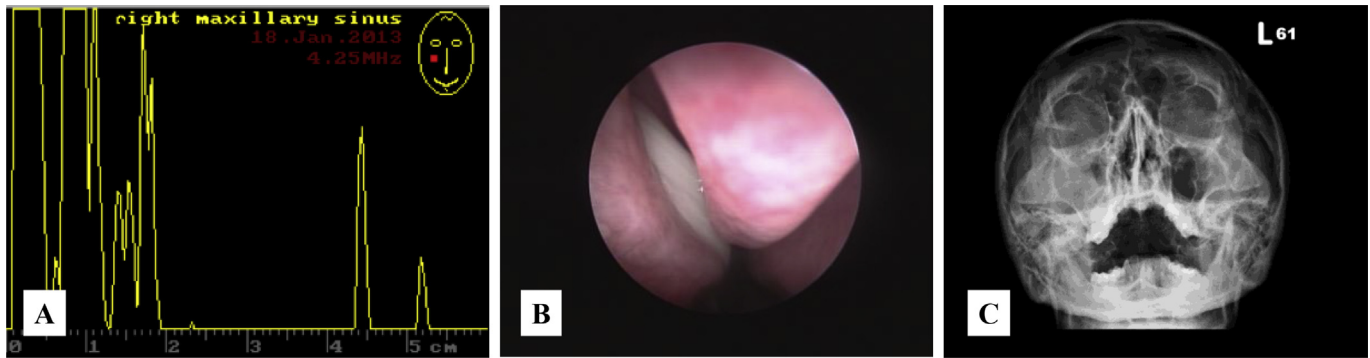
A 39-year-old male presented with symptoms of rhinosinusitis for 4 days. (A) Sinus ultrasound detected fluid in right maxillary sinus, (B) rigid nasal endoscopy disclosed mucopus from right middle meatus, and (C) plain film found total opacity of right maxillary sinus. All exams supported the diagnosis of acute maxillary sinusitis.
